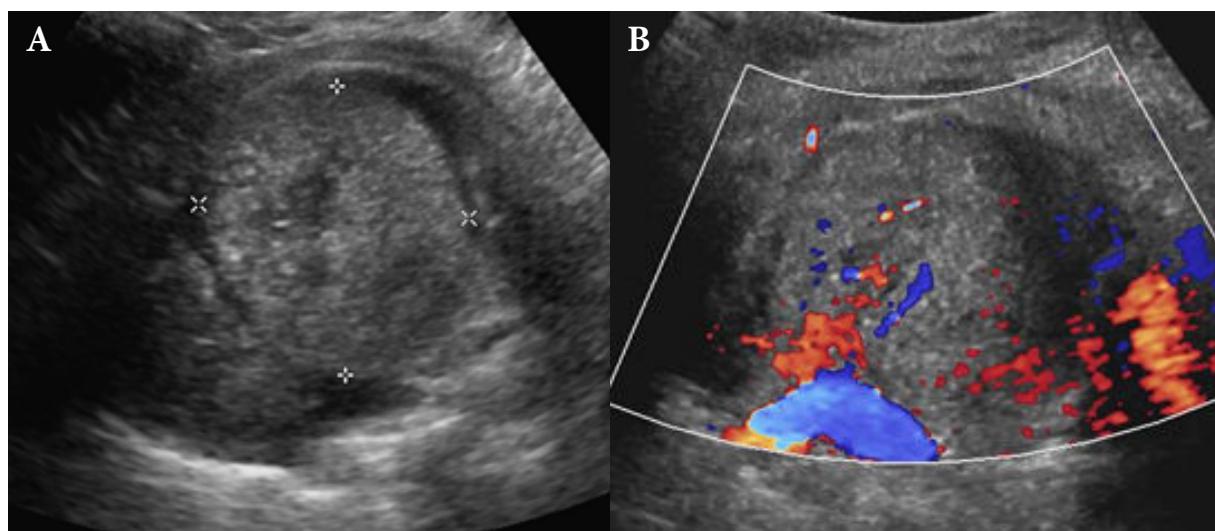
The ultrasonography of the chest (A) showed a 4.7x4.4 cm heterogeneous hyperechoic mass-like lesion in the location of the left thymic lobe. (B) There were a few foci of vascular flow within the lesion in color-mode sonography.
